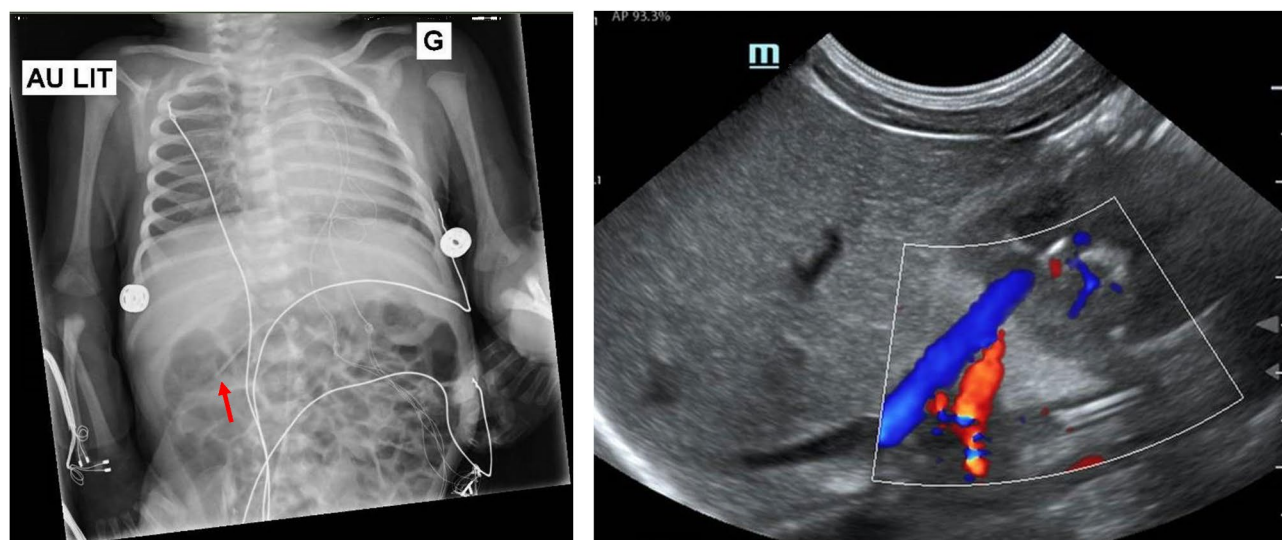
X-Ray and ultrasound showing the end of the venous central catheter into the right renal vein (red arrow showing the catheter tip)
